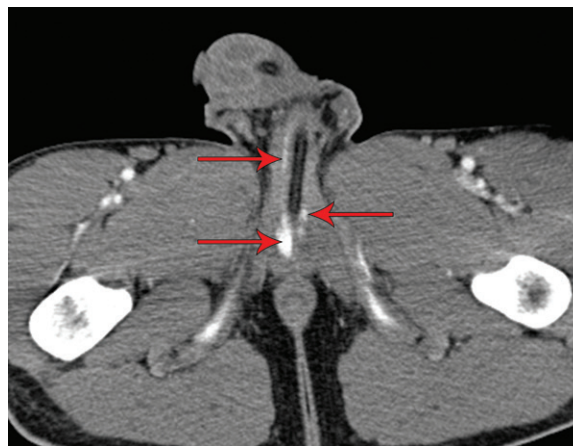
CT pitfall: contrast material pooling in a 22-year-old man. Axial CT angiogram below the level of the inferior pubic rami shows homogeneous asymmetric contrast material pooling at the base of the penis (arrows), which may be misinterpreted as active arterial extravasation.
